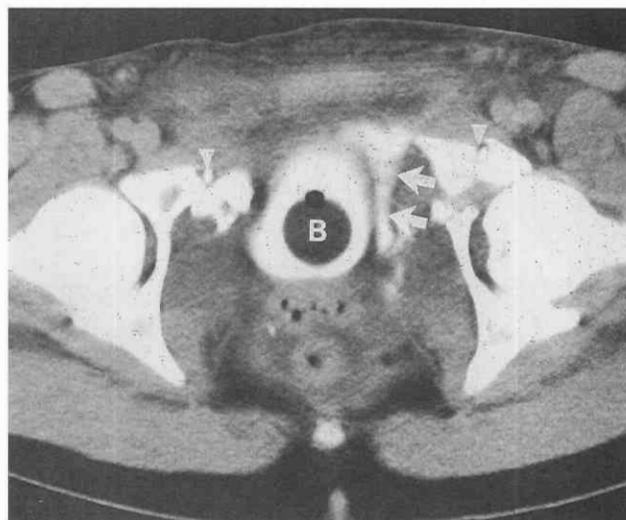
Extraperitoneal bladder rupture. CT cystogram via bladder catheter (B) shows extravasation of contrast agent into the left perivesical space (arrows). Note the bilateral pubic fractures (arrowheads).
